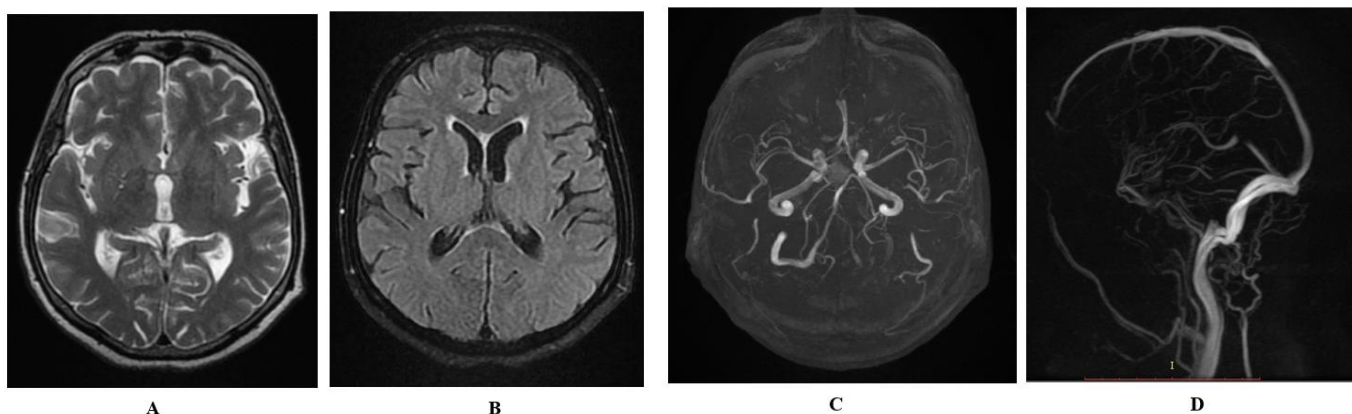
Patient V., 58 years old, with Leriche's syndrome and dyscirculatory encephalopathy. On MRI: A, B - signs of atrophy of the cortex and substance of the brain. C – MR angiography of cerebral vessels reveals: moderate decrease in blood flow in the siphon of the right ICA, moderate narrowing and decrease in blood flow in the A1 segment of the right ACA, local narrowing and decrease in blood flow in the M2 and M3 segments of the left MCA, narrowing and decrease in blood flow in both PCA, tortuosity in the course of the peripheral branches of both MCA, narrowing and decrease in blood flow in the left VA. D – MR-venogram in sagittal and coronal projection visualized the veins and venous sinuses of the brain. There is a moderate decrease in the intensity of the MR signal from the blood flow through the sagittal sinus
